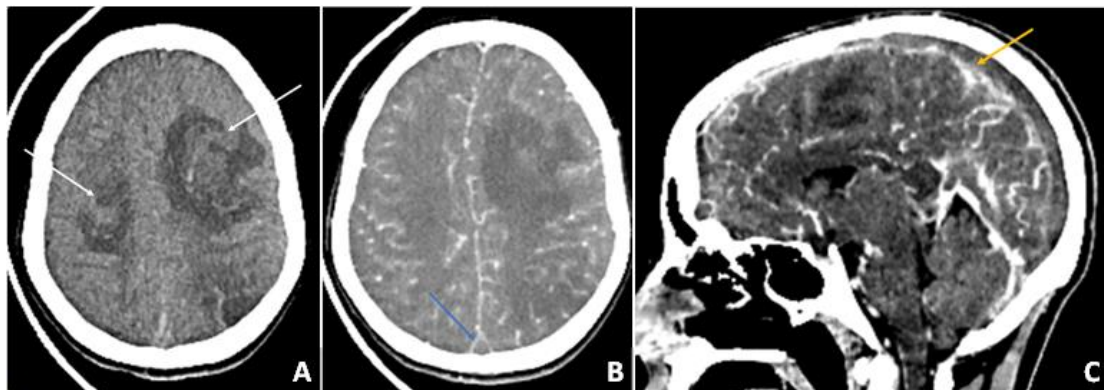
Brain contrast-enhanced CT scan: A) Hypodense cortico-subcortical folds (white arrow), mostly subcortical, left fronto-parietal and right frontal, without arterial systematization, containing spontaneously hyperdense petechiae, related to hemorrhagic changes. B) DELTA sign (blue arrow). C) Extensive superior longitudinal sinus thrombosis (yellow arrow), extended to the left transverse sinus and the right lateral sinus, as well as to the right sinus and the great vein of Galen and the internal cerebral veins
